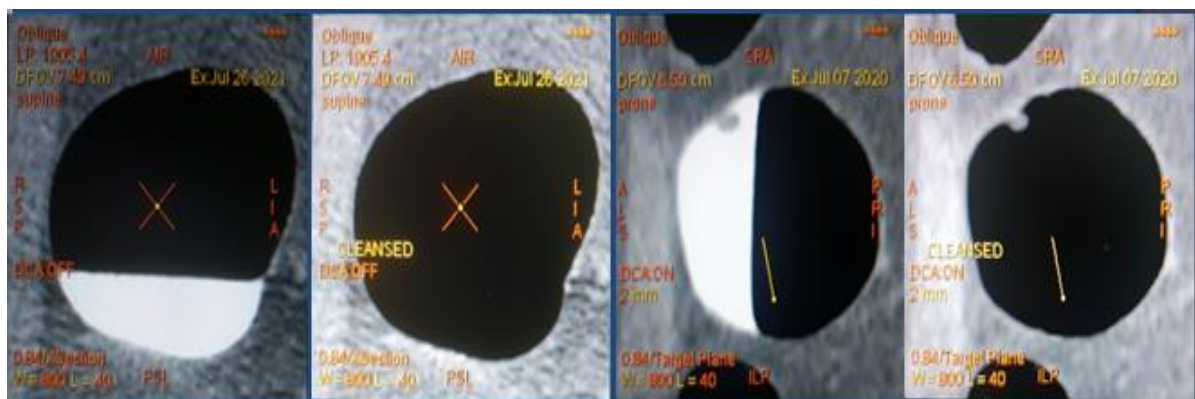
CT Colonography: "digital cleaning" (norm, polyp).
